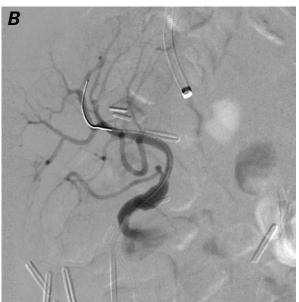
A) Intravascular ultrasonogram of the stented vascular segment reveals a well-expanded and well-apposed stent.
